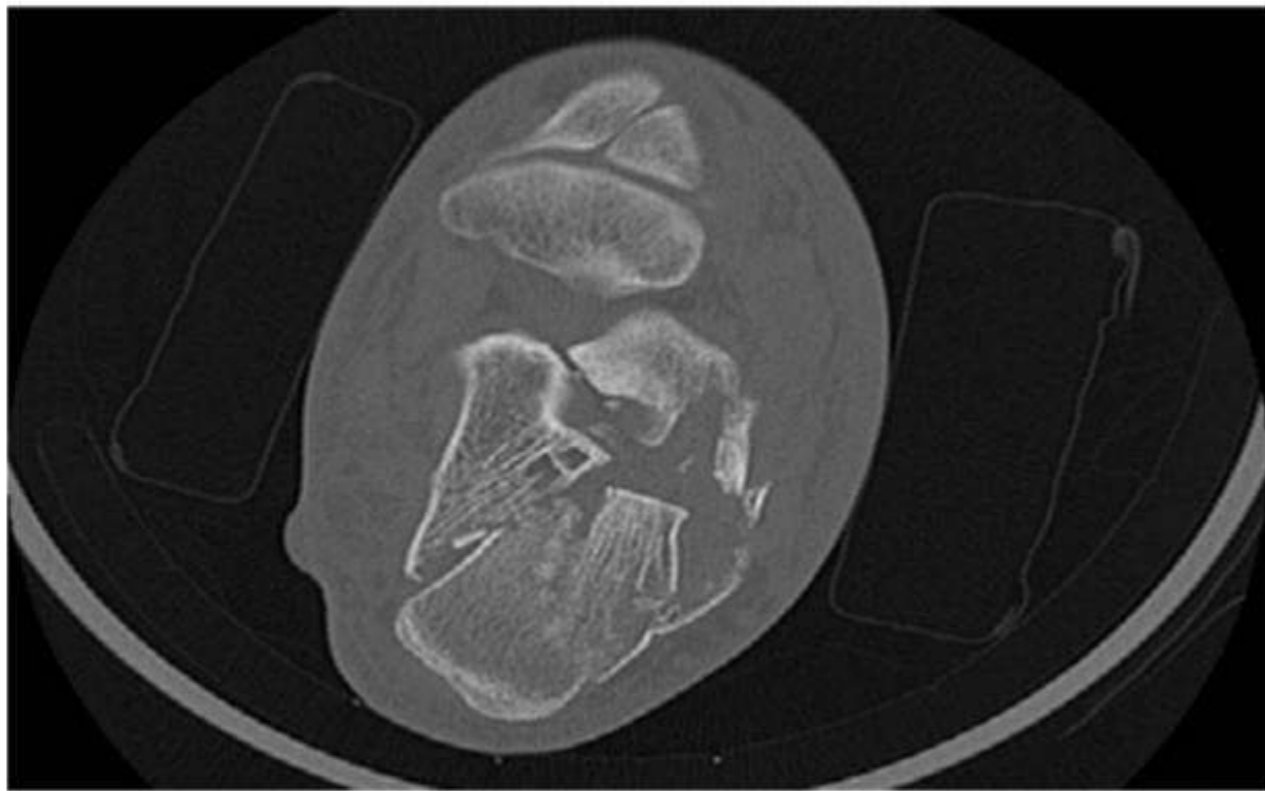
CT scan axial view left foot demonstrating calcaneal fracture.
